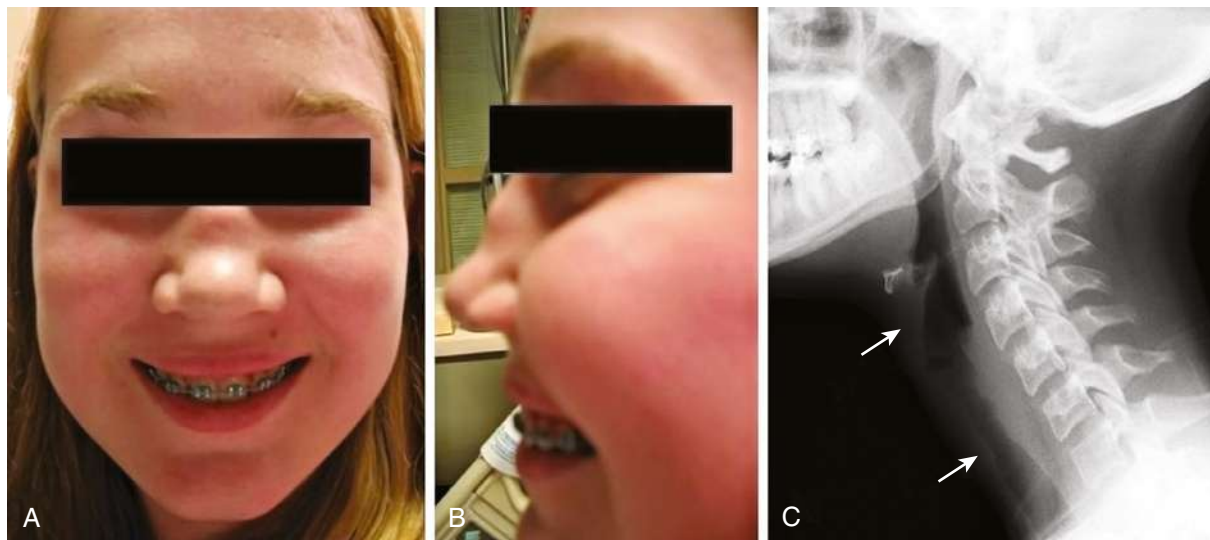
Adolescent with granulomatosis with polyangiitis. A and B, Anterior and lateral views of saddle nose deformity. C, Segment of subglottic posterior tracheal irregularity (between arrows) on lateral neck radiograph.
